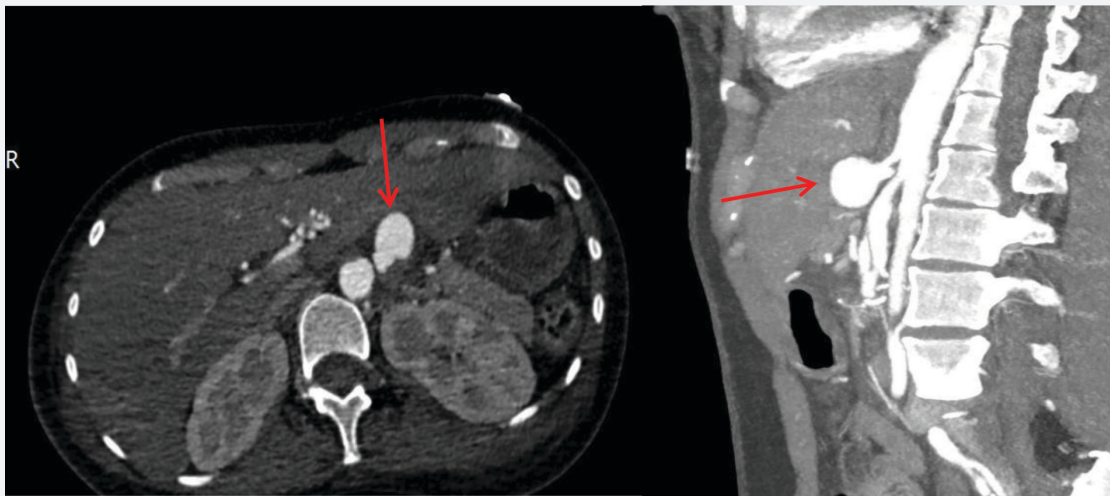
CT Aortogram A. There is a new finding of saccular outpouching seen in the celiac trunk (as pointed by the red arrow) approximately measuring 1.7x 1.7cm (W x AP) with mural thrombus formation and tiny intimal flap noted. B. 3D Reconstruction.
